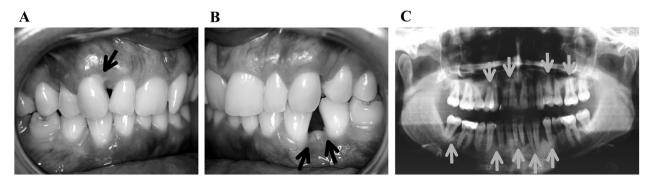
Clinical aspect and Orthopantomograph image of a representative patient diagnosed with AgP. (A) and (B): Photographic documentation of the clinical aspect; arrows point at displaced tooth and suppurations in several pockets. (C) Orthopantomograph image; arrows point at severe periodontal destruction sites with radiographic bone loss.
